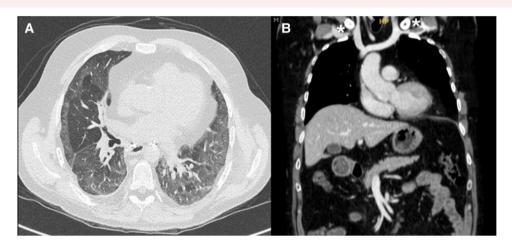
(A) Chest computer tomography with bilateral bronchiectasis, diffuse bronchial wall thickening, small areas of consolidation and pleuropulmonary fibrosis tracts. Moderate pericardial effusion. (B) Thoracic-abdominal-pelvic computer tomography with contrast, proximal deep vein thrombosis in both upper limbs, greater in the left upper limb (left subclavian vein). *marking thrombosis. Computer tomography (CT).
